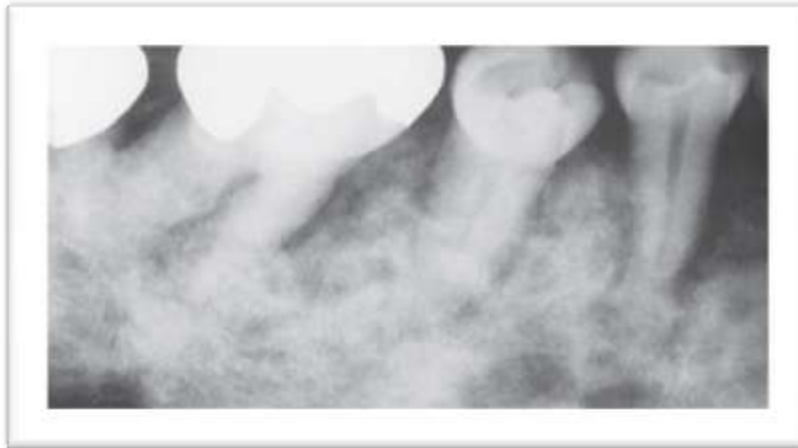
Paget's disease. Periapical film showing the "cotton wool" appearance of the bone.
